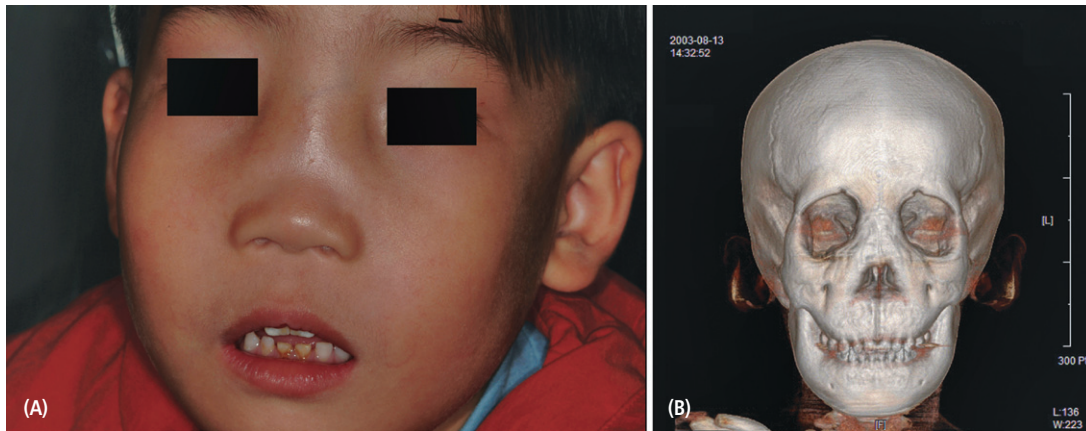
A facial photo (A) and a three-dimensional (3D) CT scan image (B) of the skull, both demonstrating the classic facial features of craniometaphysal dysplasia with dramatic thickening of the nasal bones and the nasal glabellar region.
